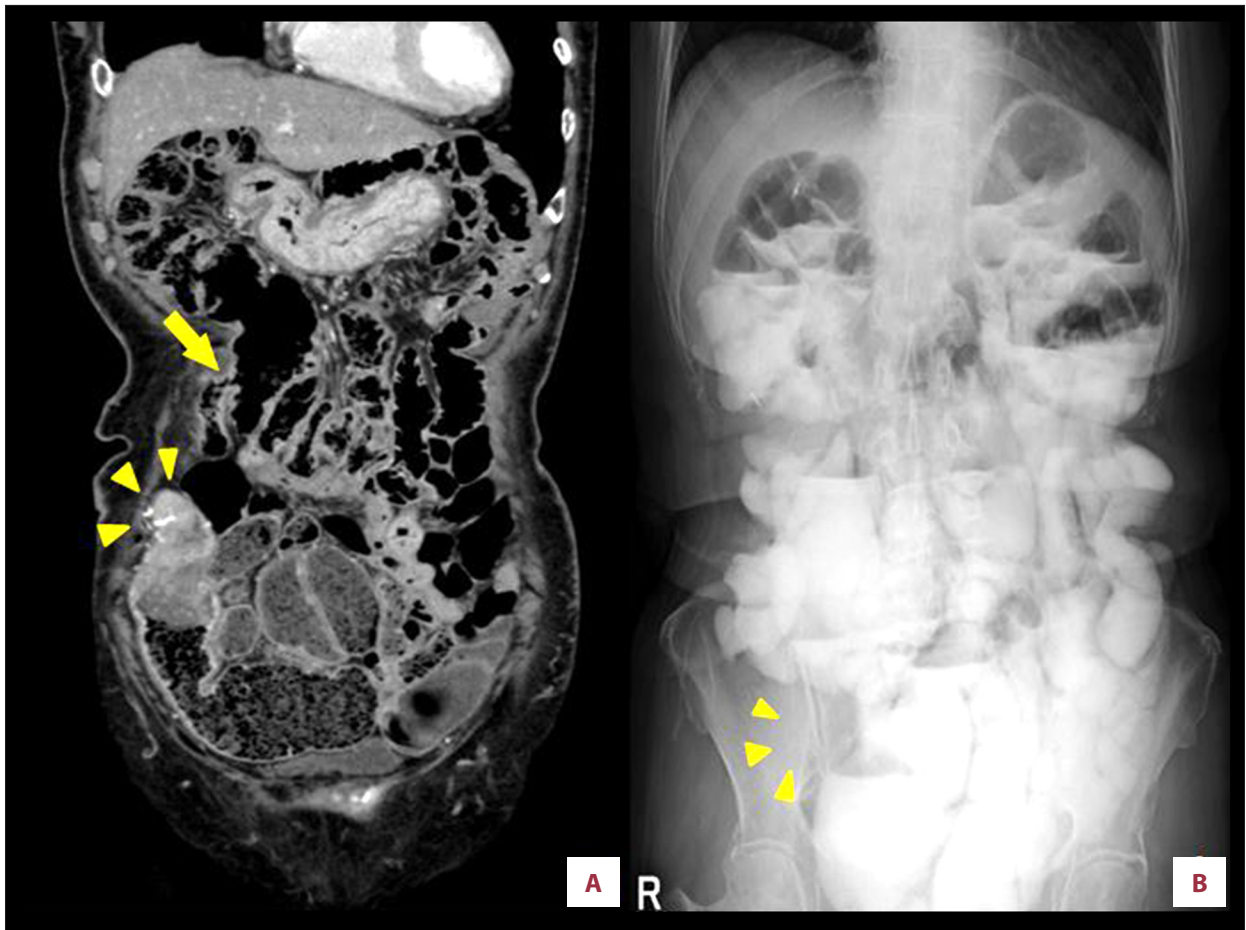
(A) Computed tomography scan image (coronal view) showing an enhanced tumor in the ileocecal area (arrowhead) and ileotransversostomy in the upper abdomen (arrow). (B) Upper gastrointestinal tract radiography showing occlusion in the lumen of the terminal ileum by a stenosing annular tumor.
